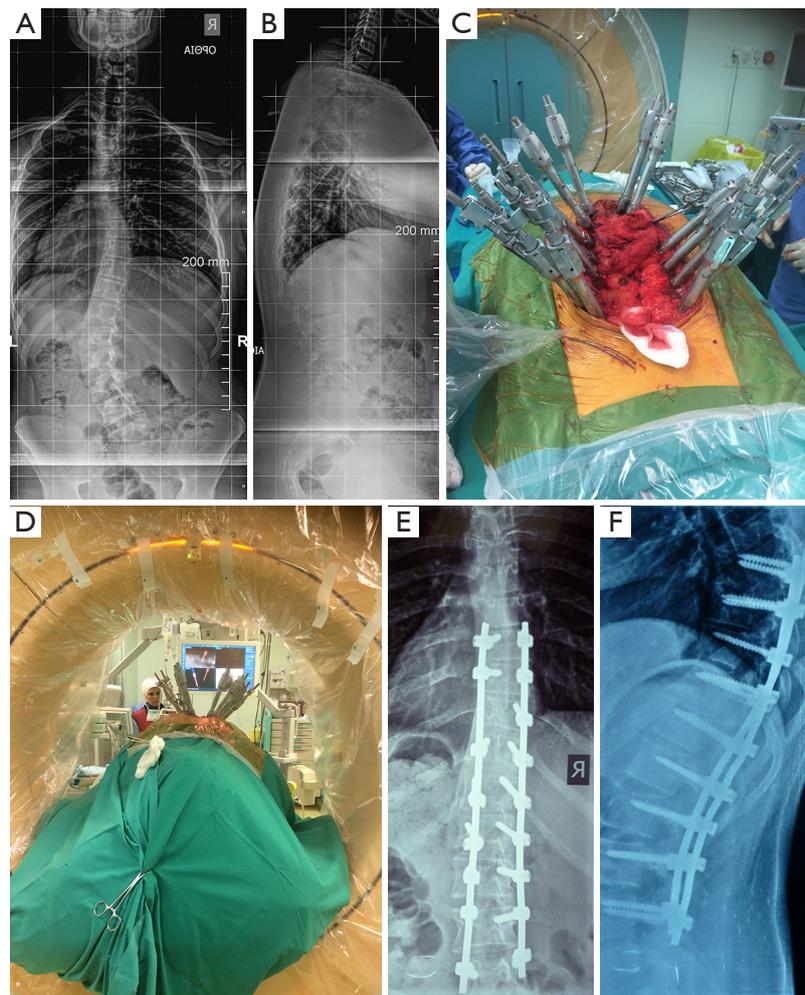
Postero-anterior (A) and lateral (B) spine radiographs of a 19-year-old male patient with Lenke 5 adolescent idiopathic scoliosis. Through a single midline skin incision, without deep dissection, multiple screws were inserted through 2-cm fascial incisions (C). The Medtronic's O-arm navigation system and the MIS longitude system (Medtronic Sofamor Danek, Memphis, TN) were used for pedicle screw and rods insertion (D). Postoperative posteroanterior (E) and lateral (F) spine radiographs revealed deformity correction utilizing MISS and spine navigation technology.
